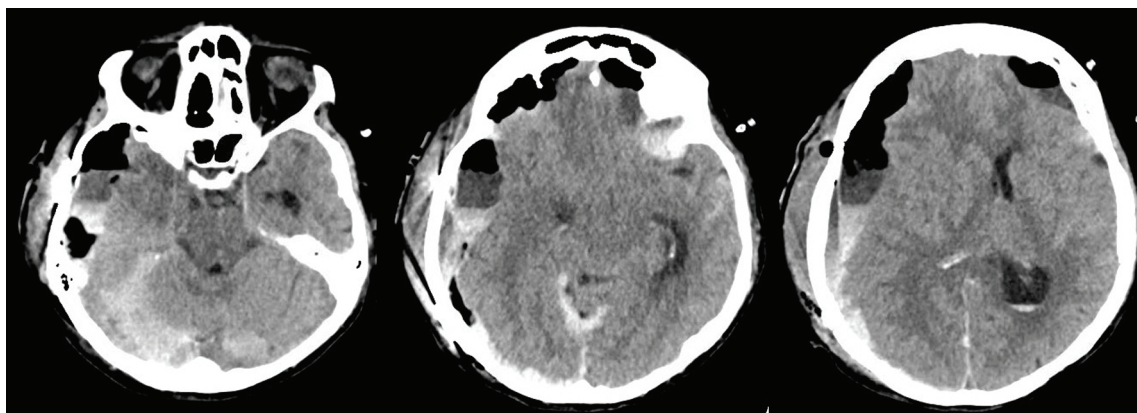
Post-surgical CT of head showing persistent acute on chronic extra-axial hematoma. There is increase in the size of left frontal lobe hematoma. Note severe parafalcine herniation much worse than the previous CT scan.
